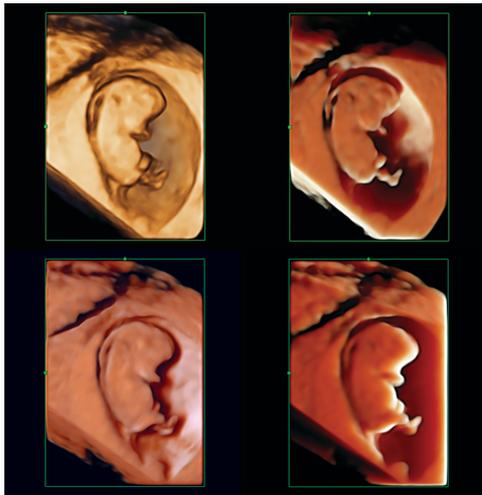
Three-dimensional ultrasound and HDlive of first trimester pregnancy (9 weeks of amenorrhea) with generalized hydrops.
